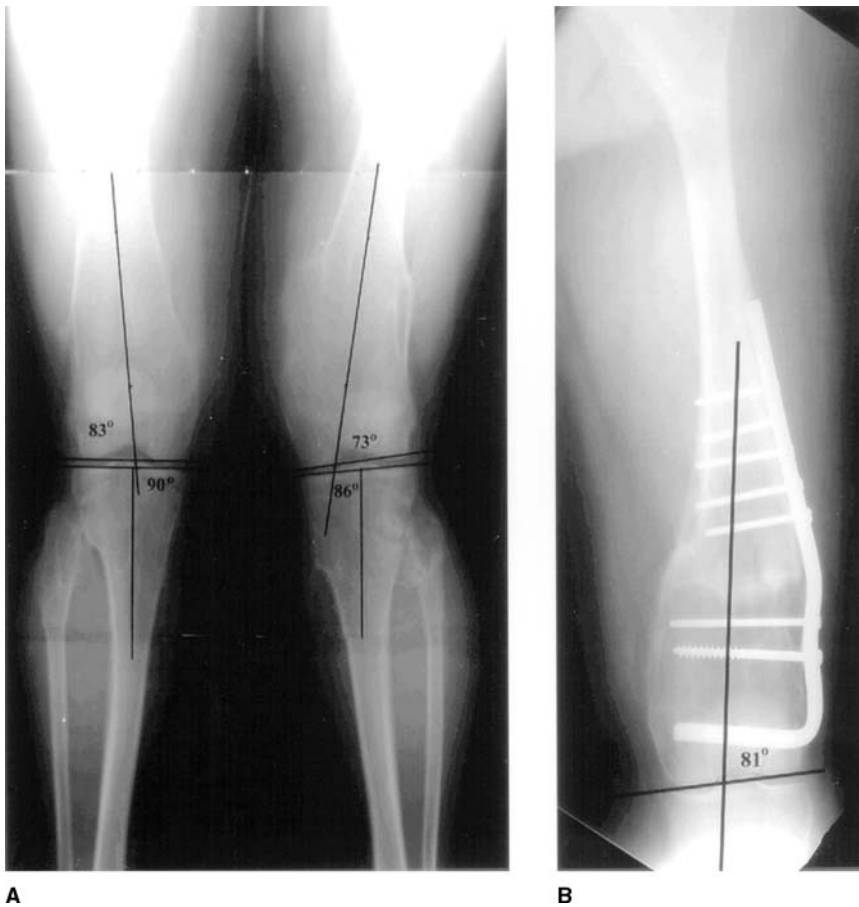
A, Standing anteroposterior radiograph of the lower extremity of a 16-year-old girl demonstrating multiple exostoses and a left femoral valgus deformity. B, Anteroposterior radiograph 6 months postoperatively of a left distal femur with the valgus deformity corrected by an opening wedge femoral osteotomy. (Reproduced with permission from Pierz KA, Stieber JR, Kusumi K, Dormans JP: Hereditary multiple exostoses: One center's experience and review of etiology. *Clin Orthop* 2002;401:49-59.)
